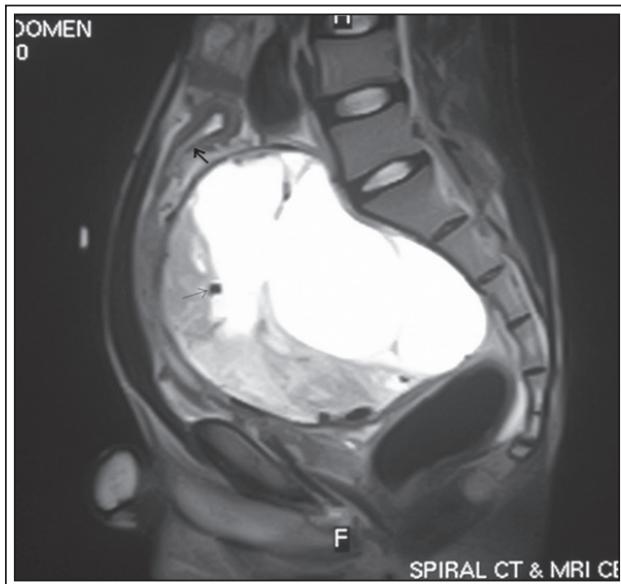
MRI T2-weighted sagittal image showing hyperintense heterogeneous mass (thick arrow) with large intra-tumoral vessels appearing as signal voids (thick arrow) displacing bladder anterosuperiorly with obliteration of flat planes with bladder.
